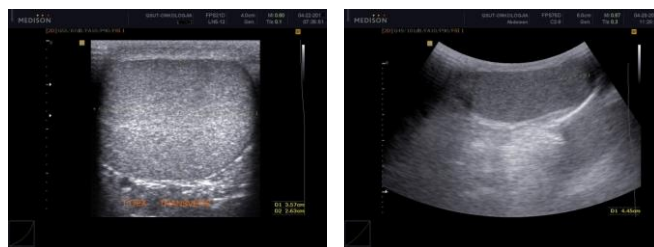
Scrotal ultrasound of two normal testes.
